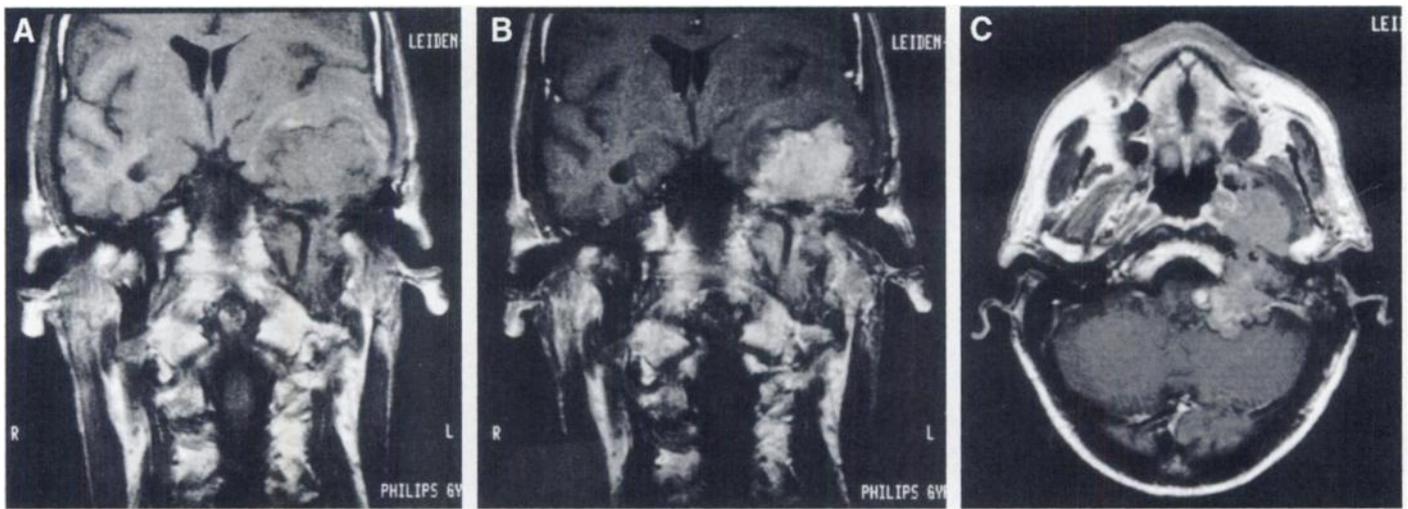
Coronal T1-weighted image (SE TR 600/TE 20) shows a large tumor in the left temporal region encasing a left carotid artery with some flow voids (A). Coronal T1-weighted image (SE TR 600/TE 20) after intravenous injection of gadopentetate dimeglumine demonstrates strong enhancement of the mass (B). Transverse T1-weighted image (SE TR 600/TE 20) after intravenous injection of gadopentetate dimeglumine better shows intracranial and extracranial extension of the tumor (C).
